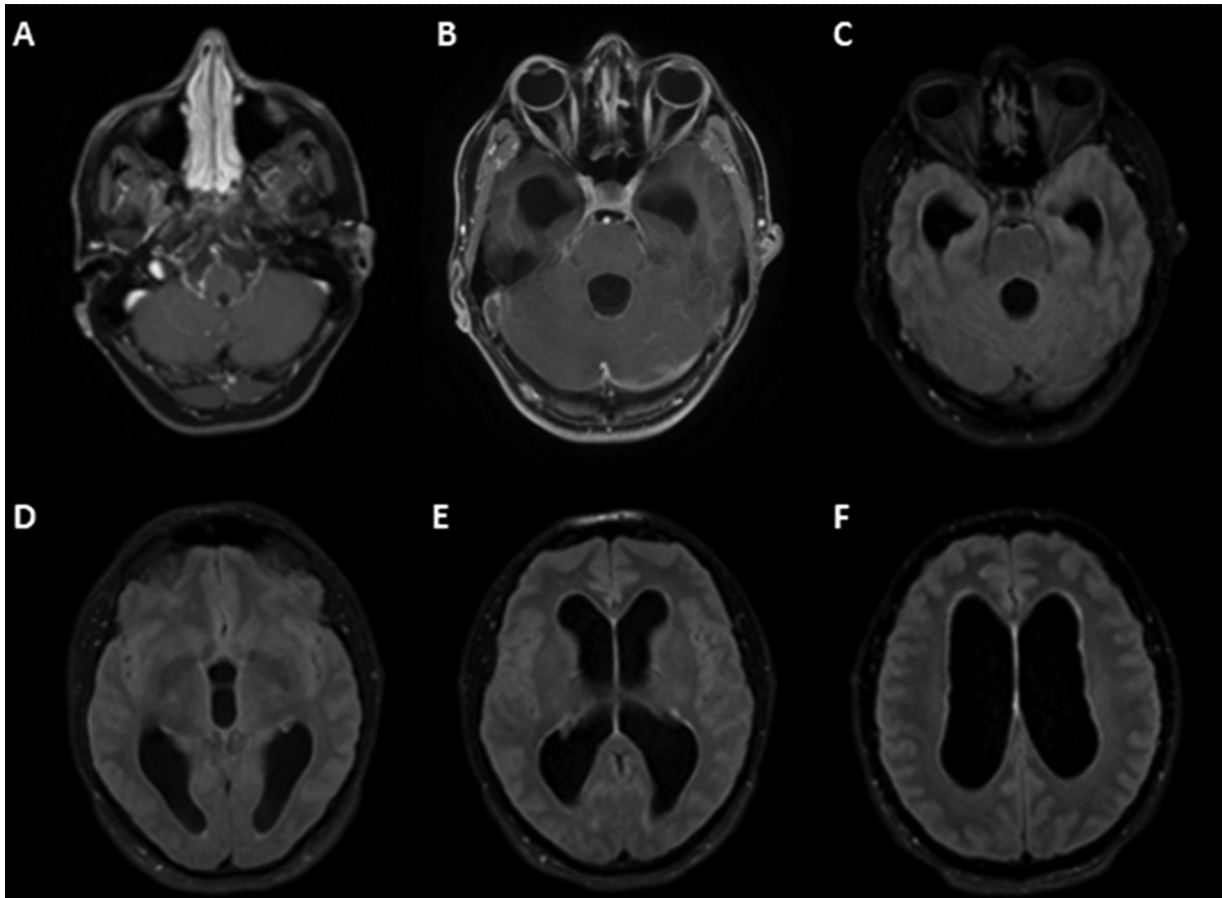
(A,B) Axial contrast-enhanced T1-weighted magnetic resonance imaging (MRI) scan revealing leptomeningeal enhancement at the base of the brain in the posterior fossa; (C–F) axial fluid-attenuated inversion recovery (FLAIR) MRI showing hydrocephalus throughout the ventricular system, without significant transudation of the cerebrospinal fluid.
